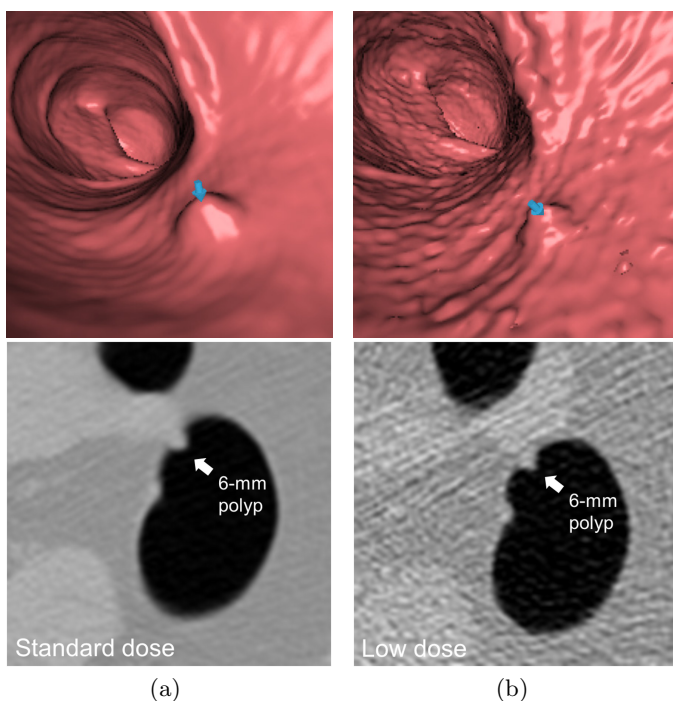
Visualization of a 6-mm polyp (indicated by arrow) in (a) standard-dose and (b) ultra-low-dose CT colonography
